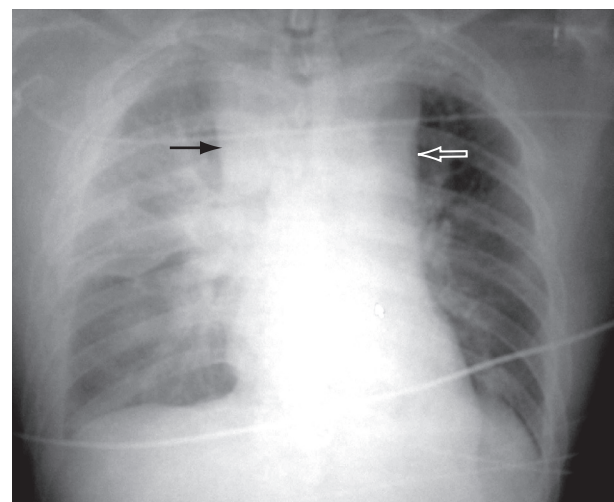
Anteroposterior radiograph of the chest showing wide mediastinum (arrows).
